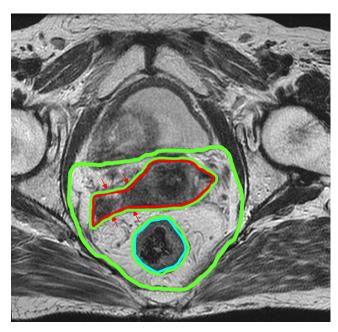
Axial T₂-weighted MR image of a patient showing the GTV (red contour), modified parametrium (green), and rectum (light blue); red arrows indicate right proximal uterosacral ligament invasion
